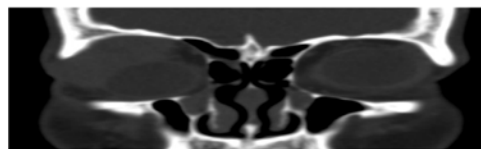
Coronal CT image demonstrate bony scalloping of the right orbital roof adjacent to a large mass arising in lacrimal fossa causing proptosis and marked displacement of the globe inferonasally.
